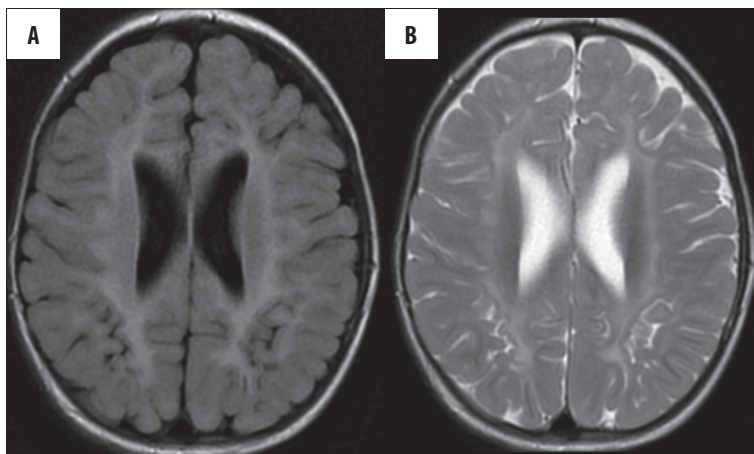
The same child as in Figure 6, aged 2 years and 4 months. Extremely rare case of cystic lesion regression. (A) FLAIR,ax; (B) FSE/T2,ax.
